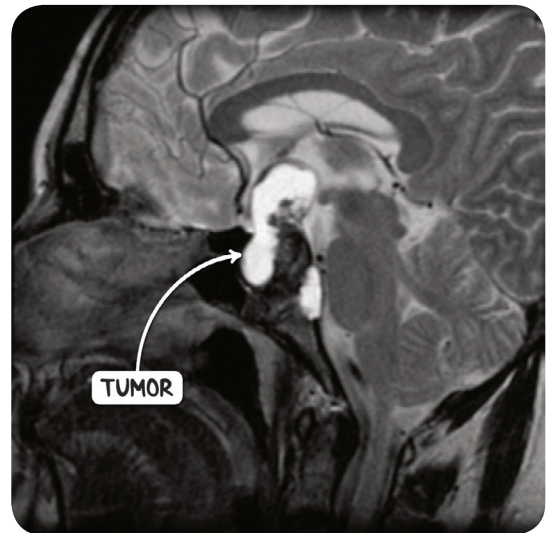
An MRI scan of the head in the sagittal plane demonstrating a craniopharyngioma, adamantinomatous subtype. The tumor has clear solid and cystic components with abundant calcification.
